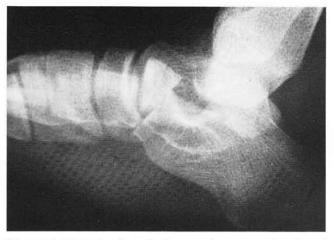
A lateral radiograph demonstrating gross malposition of the calcaneal allograft and dorsal excursion of the graft with the anterior portion of calcaneus.
